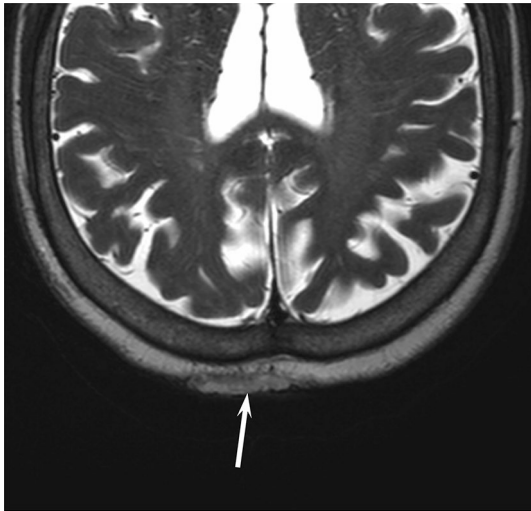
A 76-year-old woman with basal cell carcinoma. T2-weighted image shows an ill-demarcated, heterogeneously isointense, cutaneous lesion (arrow)
